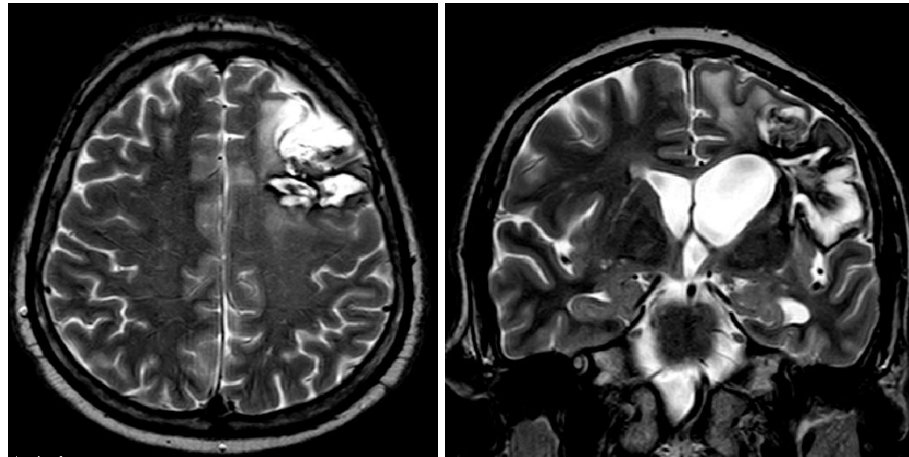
Brain Magnetic Resonance Imaging (post embolization)
